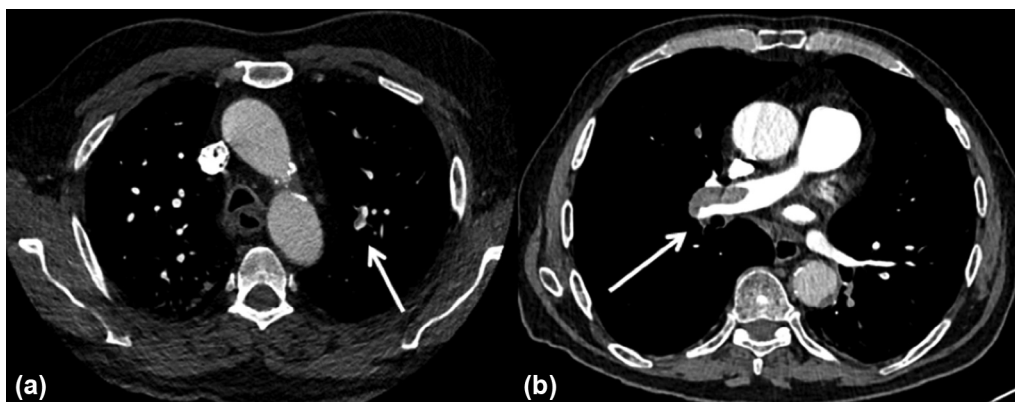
Patient with pulmonary embolism (a) with the standard pitch computed tomography under breath-hold protocol and (b) with the high-pitch computed tomography under free breathing protocol.
